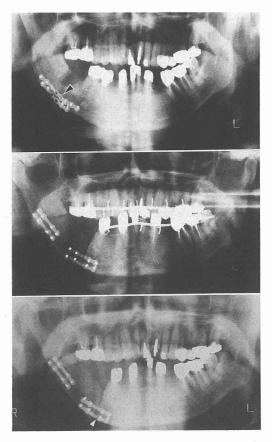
Above: Orthopantomogram showing mini-plate fracture (arrow) 5 months after insertion. Middle: Showing mini-plates fixed to the bone grafting and the mandible after removal of fractured mini-plate, segmental mandibular excision and reconstruction by use of the iliac crest.
